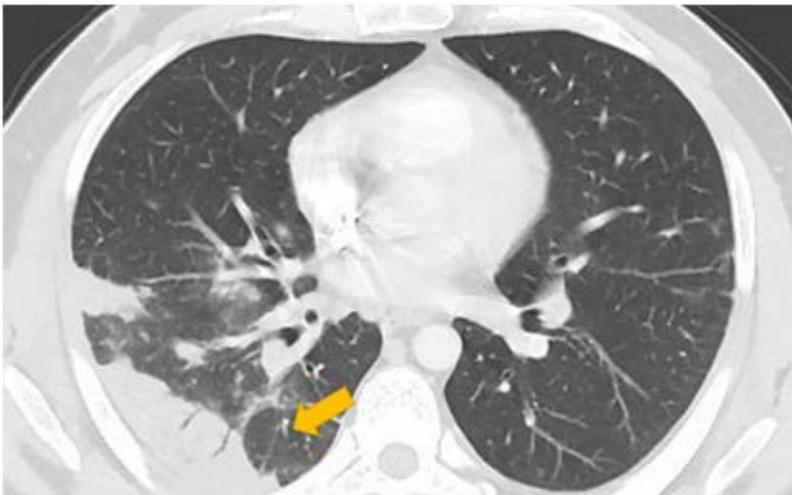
A 52-year-old male coronavirus disease 2019 patient presenting with fever and cough for 10 days. Axial CT scan shows a ground glass density with consolidation of the right lower lobe (yellow arrow).
